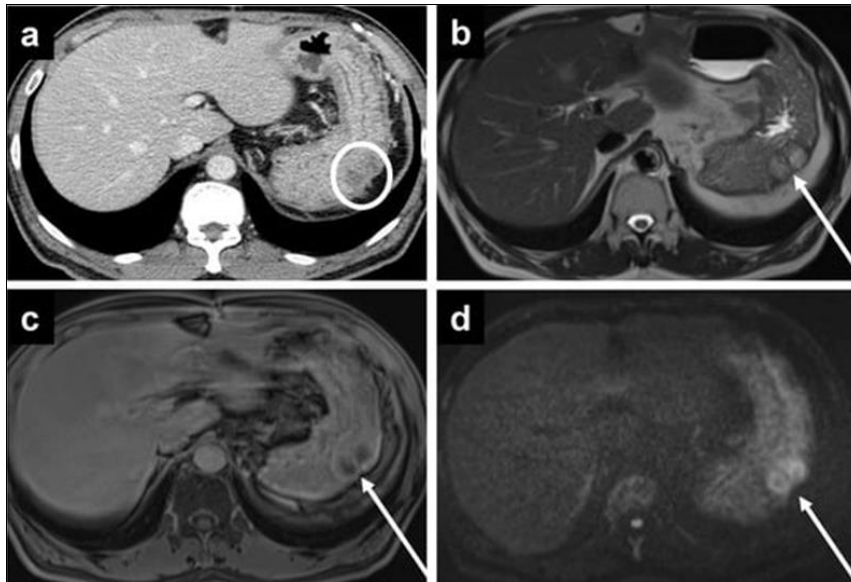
The deposits are not as well seen on (a) CT, as denoted by the white circle and are more apparent on MRI, including (b) T2W, (c) delayed (d) DWI sequences
